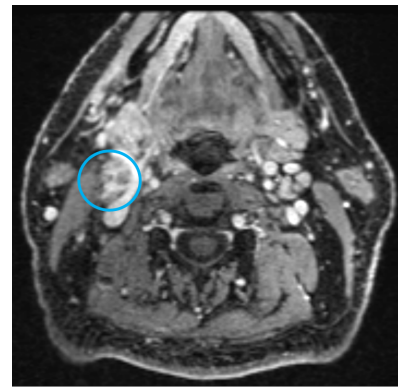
The structures that are delineated on the different scans, annotated on the MR images, from cranial to caudal. T1 weighted, contrast enhanced, turbo spin echo sequence.
